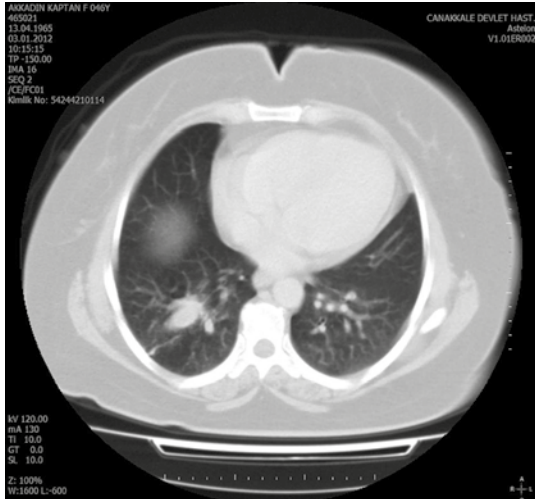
A chest-CT scan showing a smooth ovoid lesion in the right lower lobe
